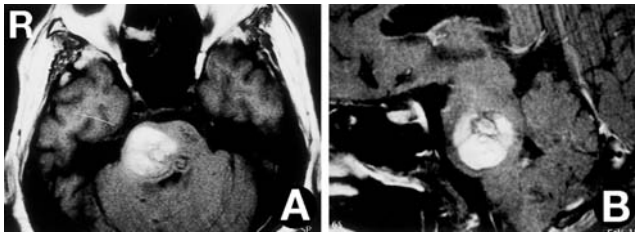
Preoperative T₁-weighted magnetic resonance images, axial view (A) and sagittal view (B), showing a pontine cavernous angioma and hematoma.
